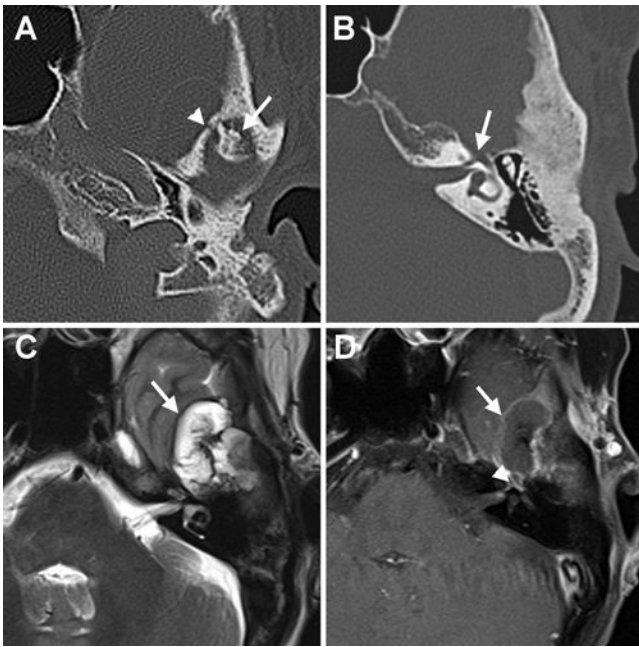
Preoperative images showing the TMJ lesion involving the condylar fossa bony wall, floor of the middle cranial fossa, and the geniculate ganglion of the facial nerve on the left. An axial bone CT image (A) shows the eroded mandibular condylar head (arrow) with a lucent defect in the medial wall of the bony condylar fossa (arrowhead). A more superior axial bone CT image (B) at the level of the geniculate fossa reveals dehiscence of the anterior bony margin (arrow) exposing the geniculate ganglion to the middle cranial fossa. An axial T2-weighted MR image (C) through the left middle cranial fossa demonstrates a mixed high- and low-signal lesion in the posterior floor of the middle cranial fossa (arrow) abutting the anterior temporal bone margin. With enhancement and fat saturation, an axial T1-weighted MR image (D) of the same region as in panel C shows the rim-enhancing low-signal lesion (arrow) in the floor of the middle cranial fossa with pathological enhancement of the geniculate ganglion (arrowhead) and adjacent components of the facial nerve.
